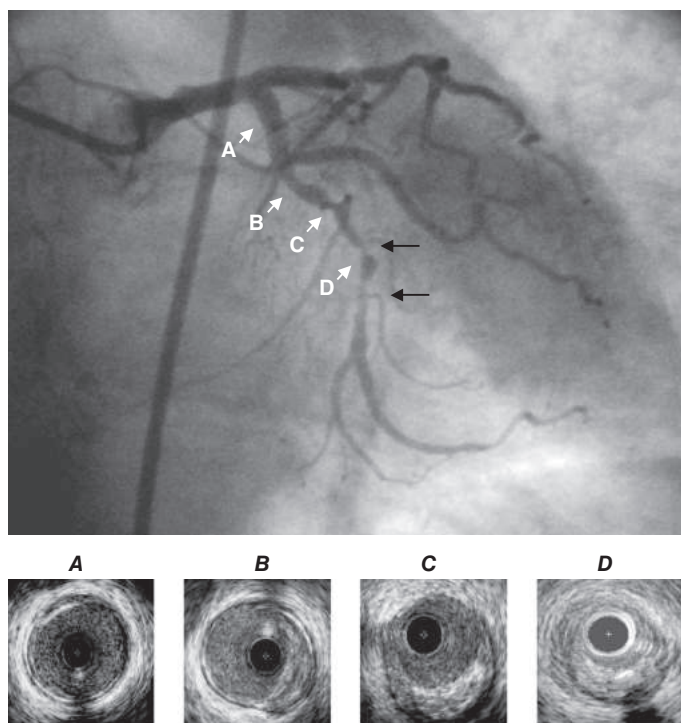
Coronary stenoses on cine angiogram and intravascular ultrasound. Significant stenoses in the coronary artery are seen as narrowings (black arrows) of the vessel. Intravascular ultrasound shows a normal segment of artery (A), areas with eccentric plaque (B, C), and near total obliteration of the lumen at the site of the significant stenosis (D). Note that the intravascular ultrasound catheter is present in the images as a black circle.
